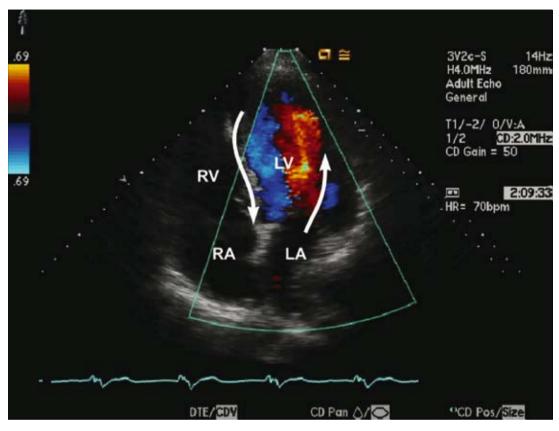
Color Doppler scale depicting flow direction and relative velocities.
